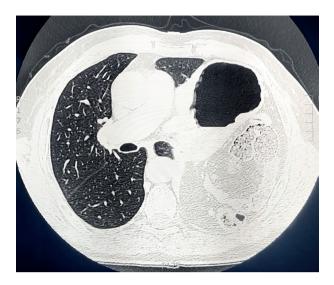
Axial CT image acquisition for pulmonary parenchyma.
